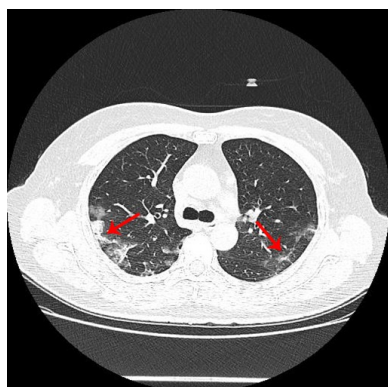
CT scan of a 57-year-old female presenting with fever, cough, dry throat, reduced lymphocyte count, increased CRP level, and normal white blood cell and neutrophil counts.
